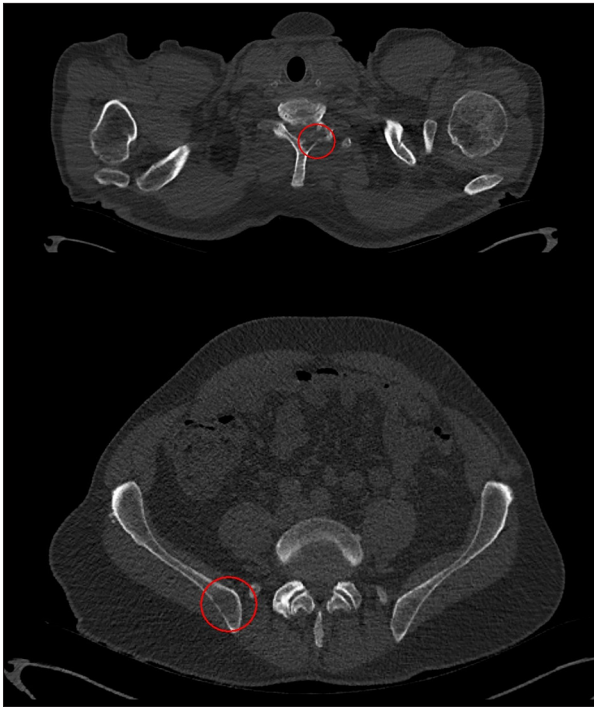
Whole-body low-dose computed tomography scan showing an osteolytic bone lesion in the seventh cervical vertebra and the right pelvis (red circles).
